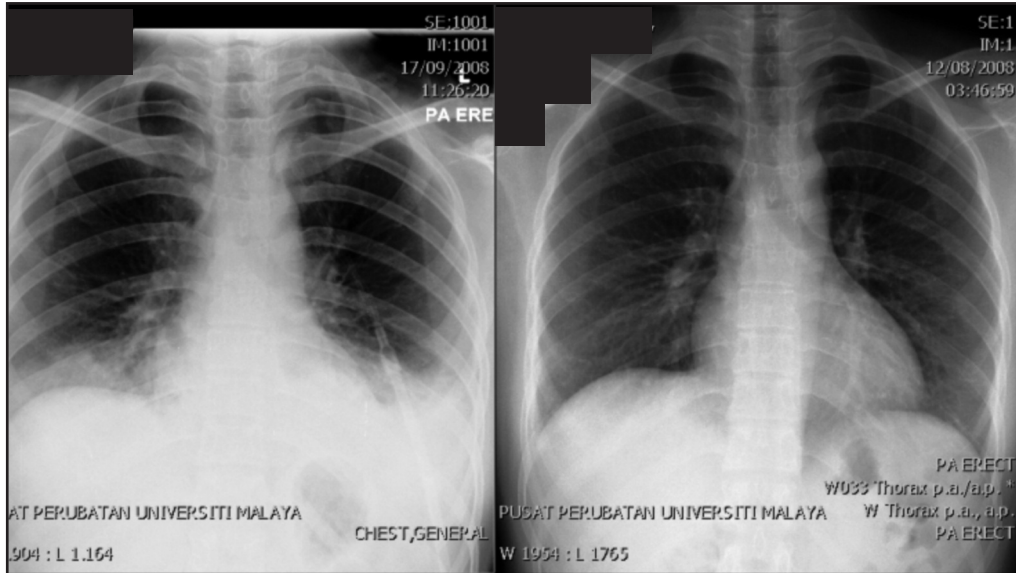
Initial chest radiograph (12/8/08) which was normal subsequently showed consolidation in both lung bases in association with a left-sided pleural effusion on several chest radiographs done later (17/9/08).
